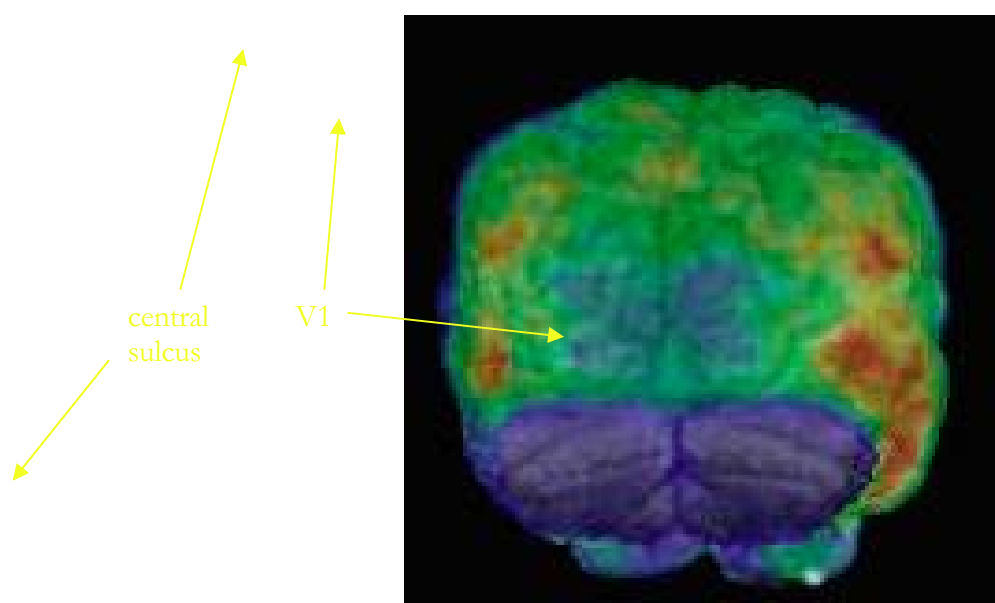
5-HT_{1A} receptor distribution map. The underlay is a coregistered anatomical MRI scan from the same subject
